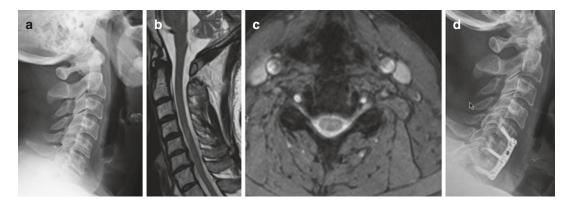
(a) Plain neutral cervical radiograph demonstrating a C2–C7 SVA of 35.1 mm and C2–C7 lordosis of 20.5 degrees. (b) Sagittal and (c) axial T2-weighted magnetic resonance imaging (MRI) demonstrates degenerative changes at C5–C6 and C6–C7 with disc collapse, disc
